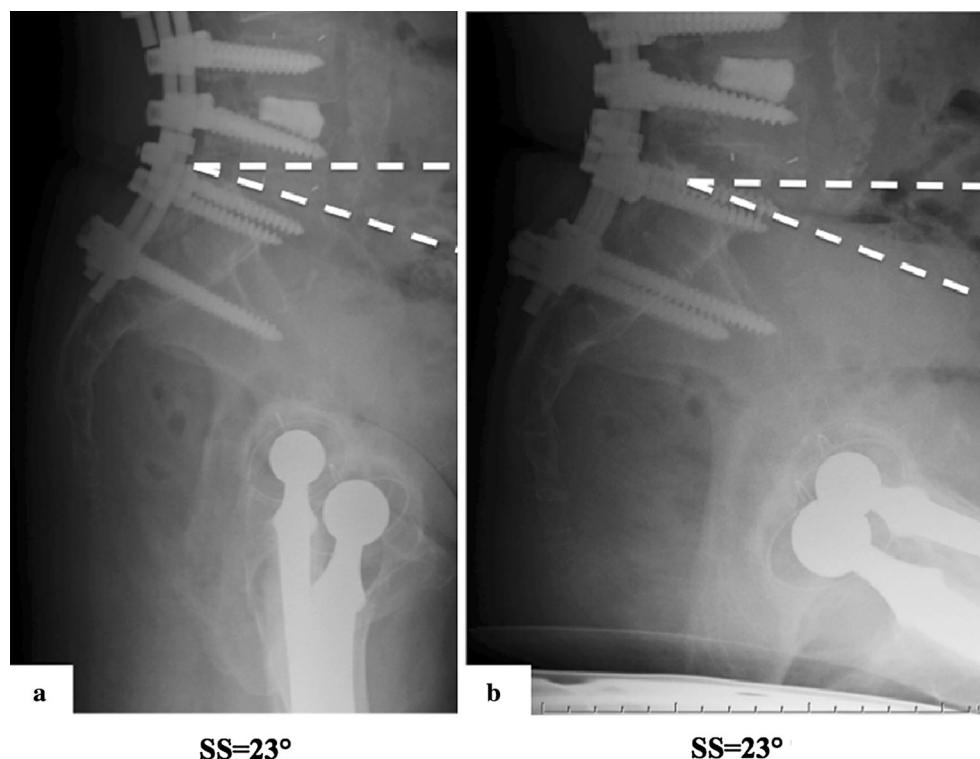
Lateral radiographs of the pelvis after the spinal long fusion with pelvic fixation (with iliac screws) while the patient was standing (a) and sitting (b). Pelvic position is not changed, and remained anteverted from the standing position to sitting position
